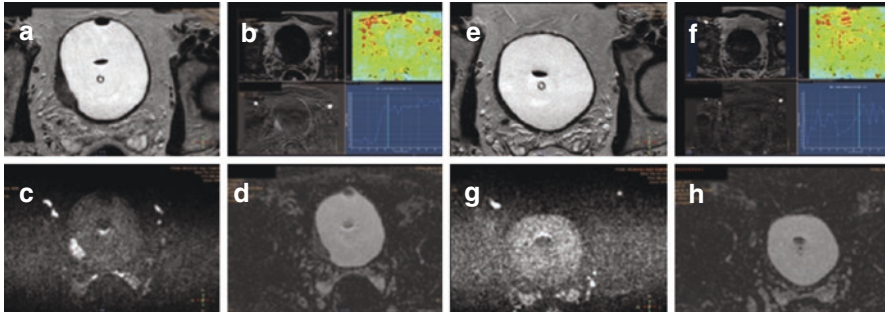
Pre-treatment images (a–d) and post-treatment images (e–h) . In the pre-treatment images, a large muscle-infiltrating lesion of the right lateral wall of the bladder is observed: hypointense in T2 (a), with enhancement after contrast medium with a type 2 contrast intensity-time curve (b); hyperintense in native DWI (c), and hypointense in ADC maps (d). The post-treatment images show the disappearance of the lesion with bladder wall returning within normal limits. In this case, there was a complete response
